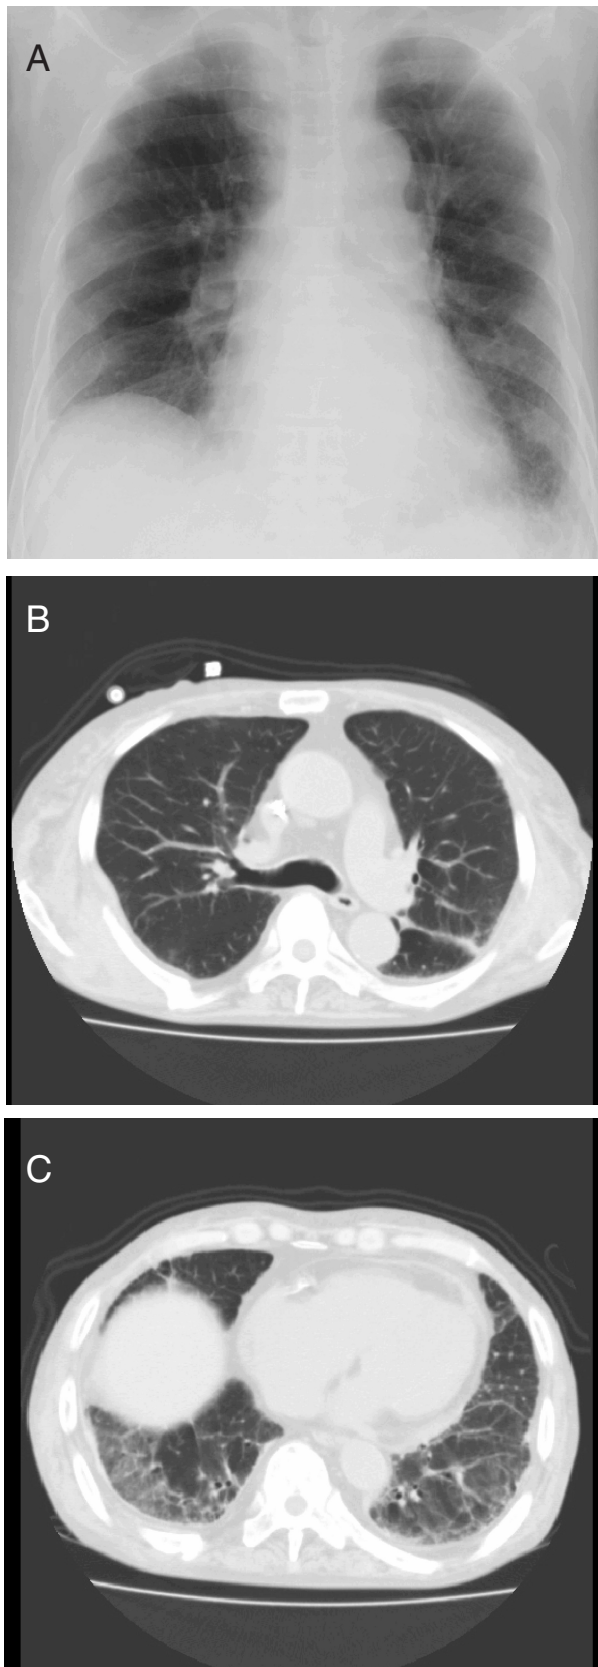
Chest radiographs and computed tomography images showing bilateral reticular opacities of the lung obtained in 2008. (A) Chest radiograph obtained in 2008. (B, C) Chest computed tomography images obtained in 2008.
